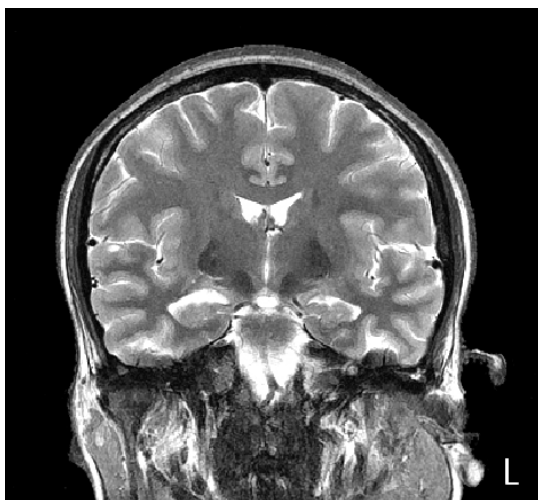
T2-weighted MRI. A coronal section.
